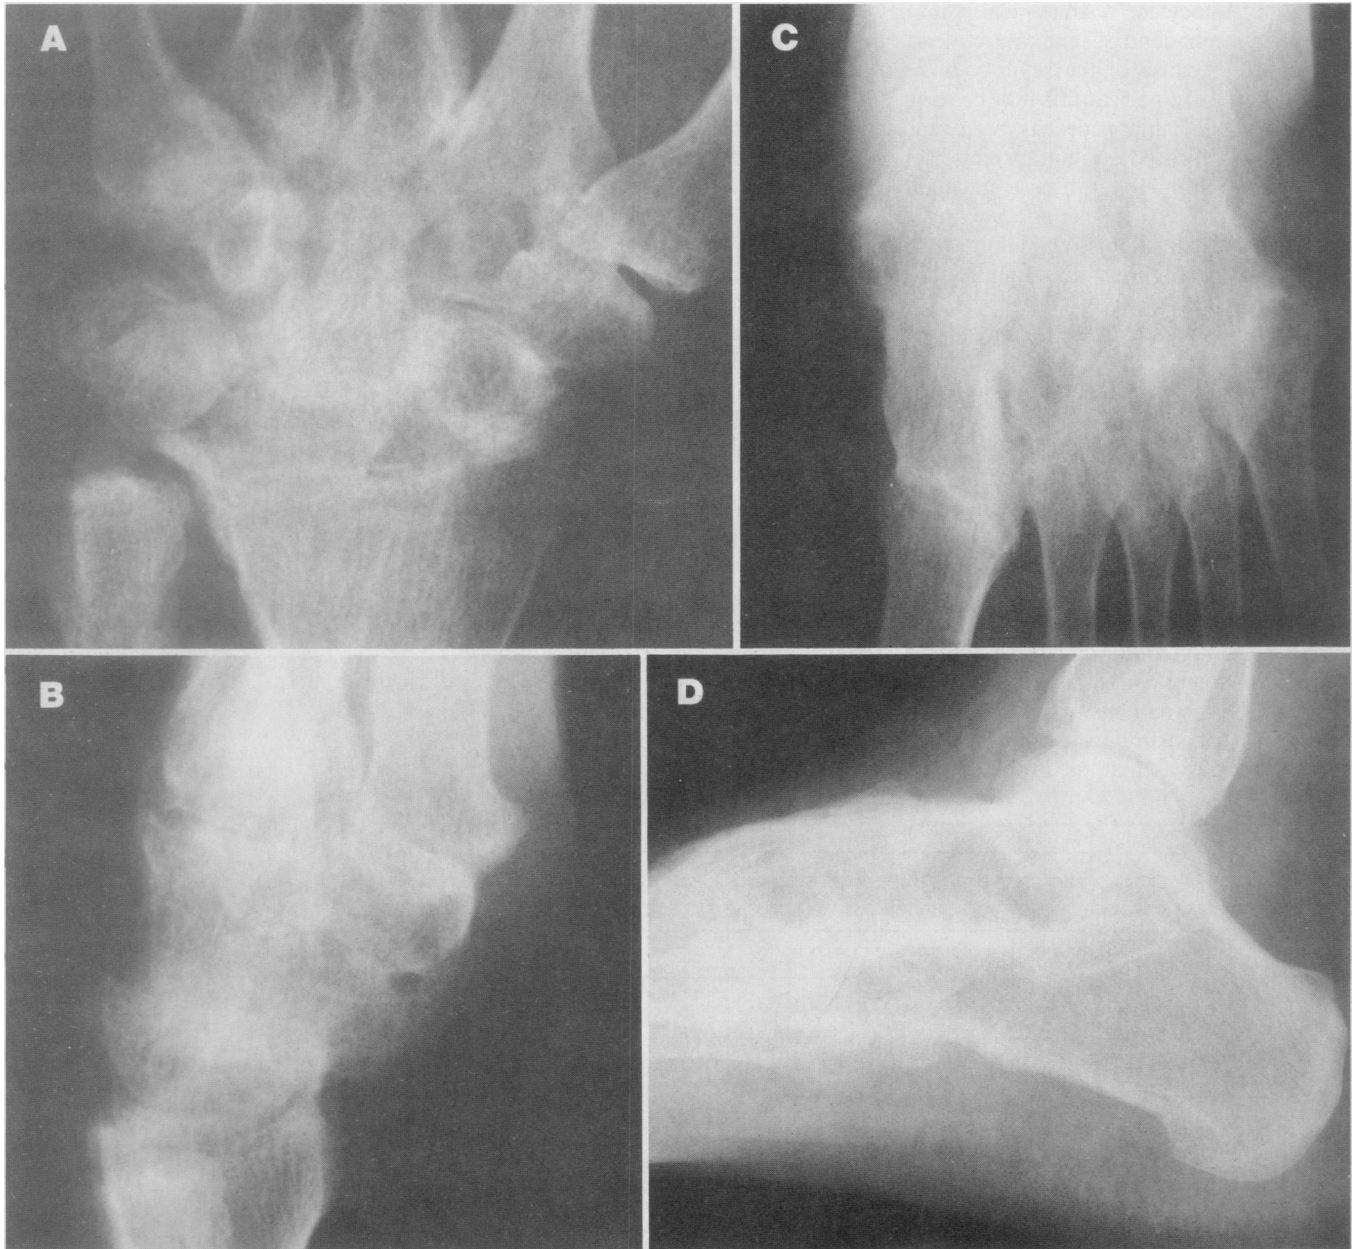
X-ray films from case 16 with typical changes of adult Still's disease. A, Posteroanterior view of the right wrist shows ankylosis of the radial carpal joint and the capitate-lunate joint. The other joints are narrowed and there are areas of erosion. B, Lateral view of the right wrist shows the areas of ankylosis. C, Anteroposterior view of the tarsal region of the right foot shows complete bony fusion of all of the visualized joints, including the metatarsal-tarsal area. No remaining joint surfaces are identified, other than a small area between the middle and medial cuneiforms. D, Lateral view of the right ankle shows bony ankylosis of the subtalar joint. There is also fusion in the area of the midtarsal joints. There is generalized demineralization of the bony structures, with coarsening of the trabecular pattern. (Courtesy of R. F. Kilcoyne, MD, Department of Radiology, University of Washington.)
